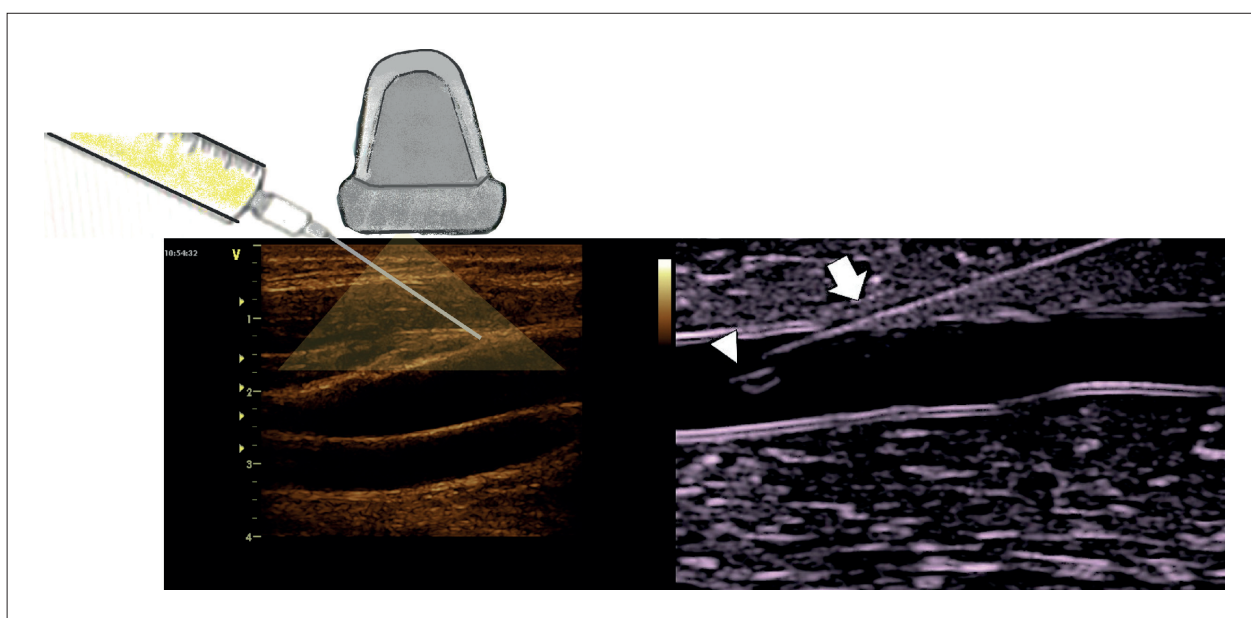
Needle positioning and orientation in the longitudinal cannulation technique. The needle can be visualized along its entire length when fully aligned within the ultrasound beam, with the needle tip recognized by its beveled appearance.
